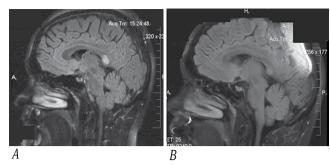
ADC Map MRI of Patient A. *A*: day 1 of hospitalization, low signal intensity in the splenium projection; *B*: day 13 of hospitalization; average signal intensity in the splenium projection.
